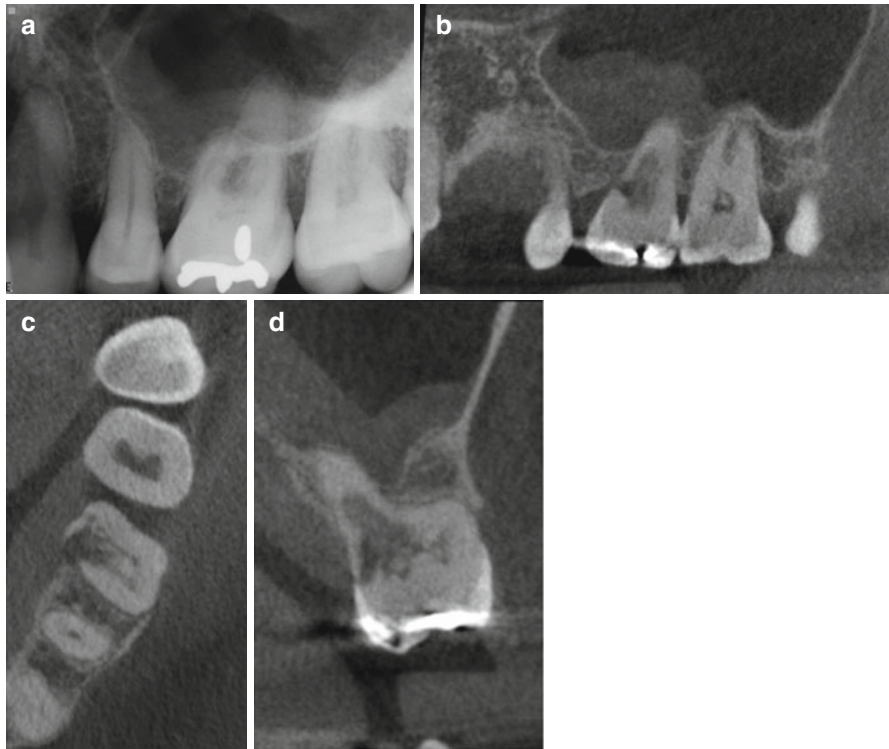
(a) Periapical radiograph of tooth #14. Symptoms included spontaneous pain and abnormal sensitivity to cold. After clinical examination and testing, the diagnosis was symptomatic irreversible pulpitis with symptomatic apical periodontitis. (b) CBCT sagittal view of tooth #14 showing an invasive cervical resorptive defect (ICR – Heithersay Class IV) that cannot be detected on the periapical radiograph. (c) Axial view demonstrating the palatal and mesial location of the defect. (d) Coronal view demonstrating the internal aspect of the ICR defect, rendering tooth #14 non-restorable. A change in treatment plan was made and the patient was referred for extraction
